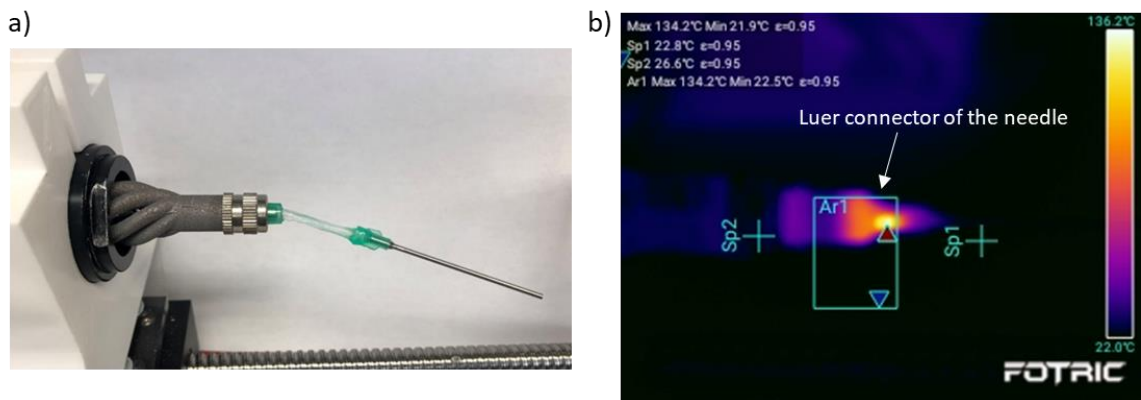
High power ultrasonic vibration causes the failure of the Luer connector of the needle.
